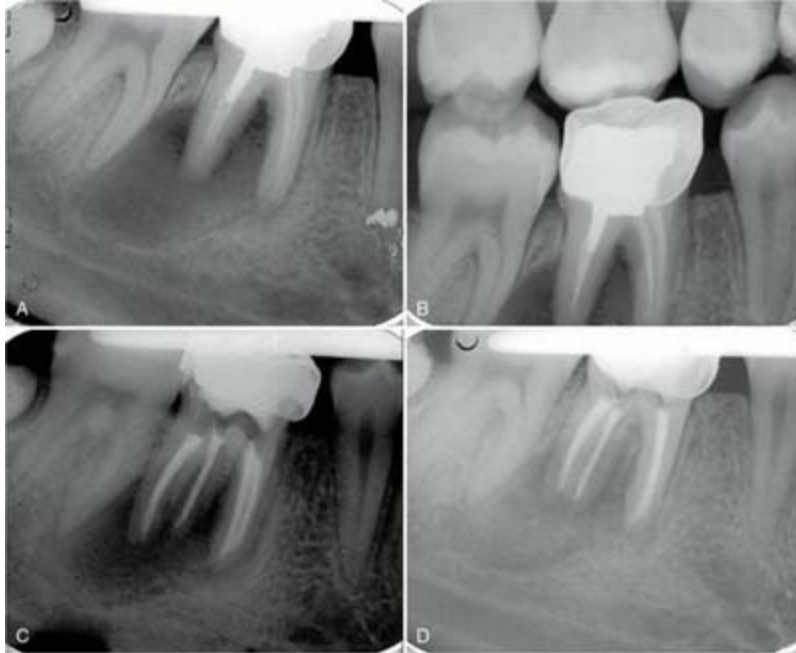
Nonsurgical retreatment of tooth #30. An additional root was located and treated. A, Note inadequate endodontic treatment and large periapical lesion. B, Bitewing radiograph. C, Retreatment after post removal. D, Eighteen-month recall radiograph indicates periapical healing.
